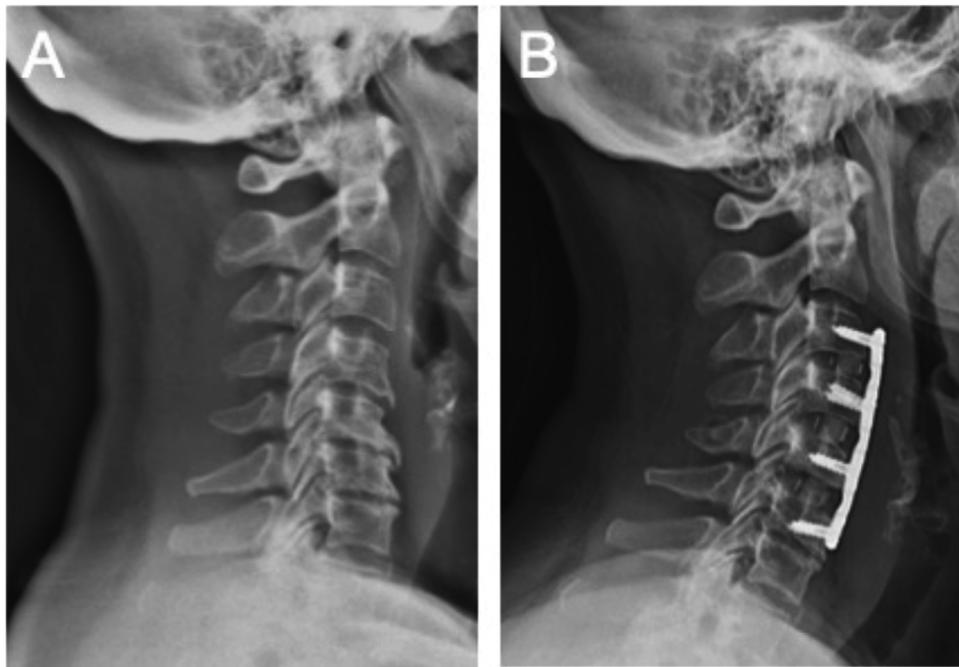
A) Pre- and B) post-operative lateral cervical spine X-rays following multi-level anterior cervical discectomy and fusion with interbody grafts and plate.
